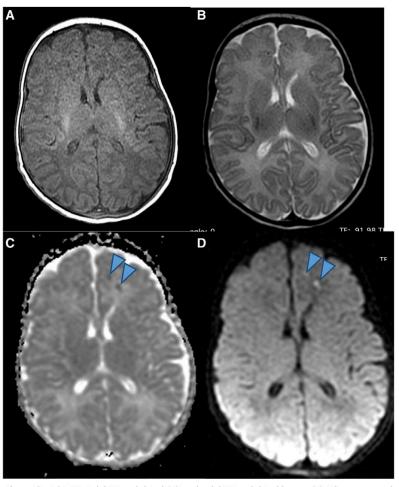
This is the patients' MRI: Axial T1-weighted (A) and axial T2-weighted image (B): There are no signal abnormalities in the brain parenchyma. Axial DWI image (C) and axial ADC image (D) show 2 small foci of restriction in the left frontal subcortical white matter compatible with acute ischemic lesions (arrowheads).
